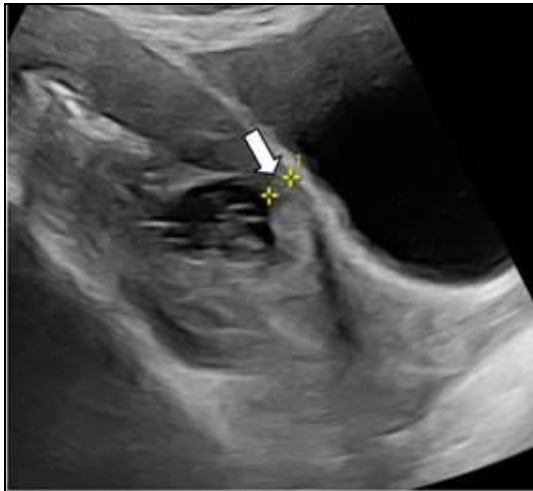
Mid-sagittal ultrasonography of the uterus reveals a gestational sac with markedly thinned anterior myometrium measuring approximately 2 mm anterior to the sac.
